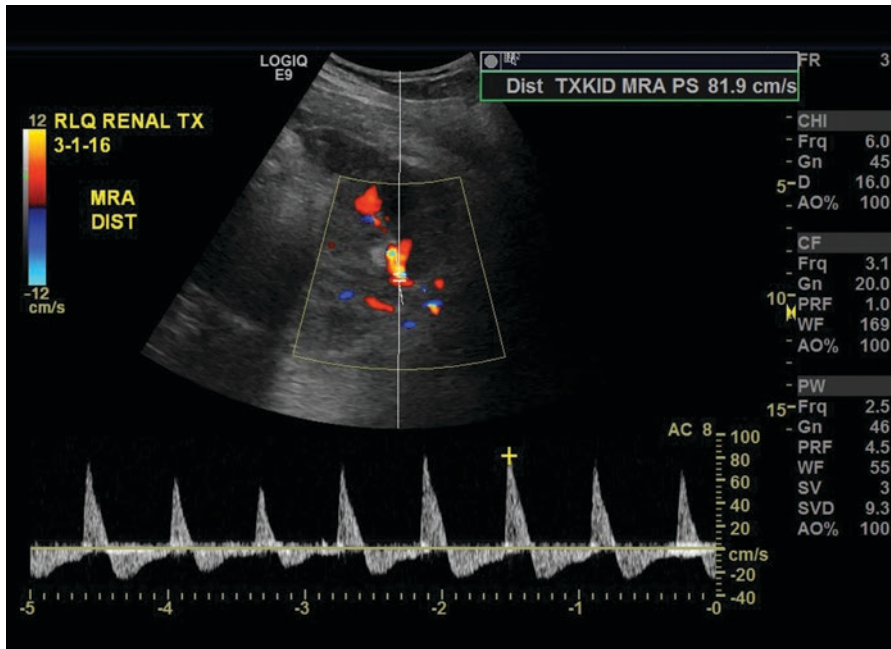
Spectral Doppler US shows main renal artery flow reversal as a result of venous thrombosis
